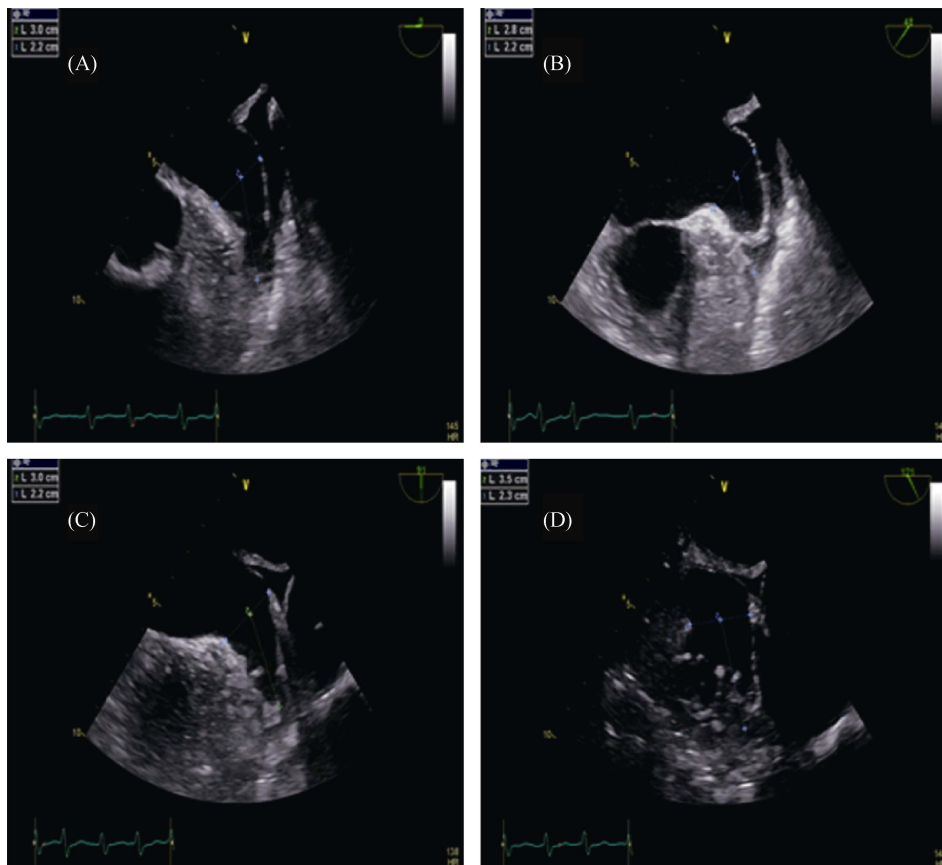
2D transesophageal echocardiography image at 0° (A), 45° (B), 90° (C) and 135° (D) angles showing the single lobe of the left atrial appendage, which was similar to a chicken wing in shape. No thrombus was detected in the left atrium or left atrial appendage.
